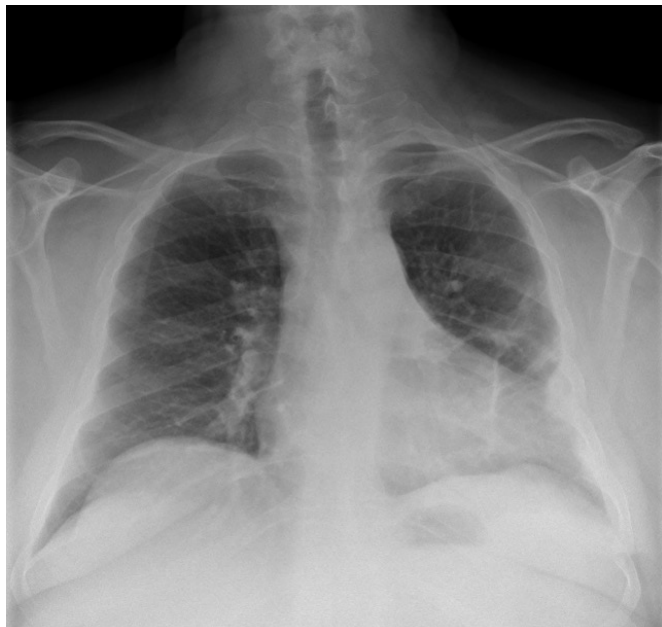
Chest radiograph at one month postdischarge during follow up clinic appointment.
